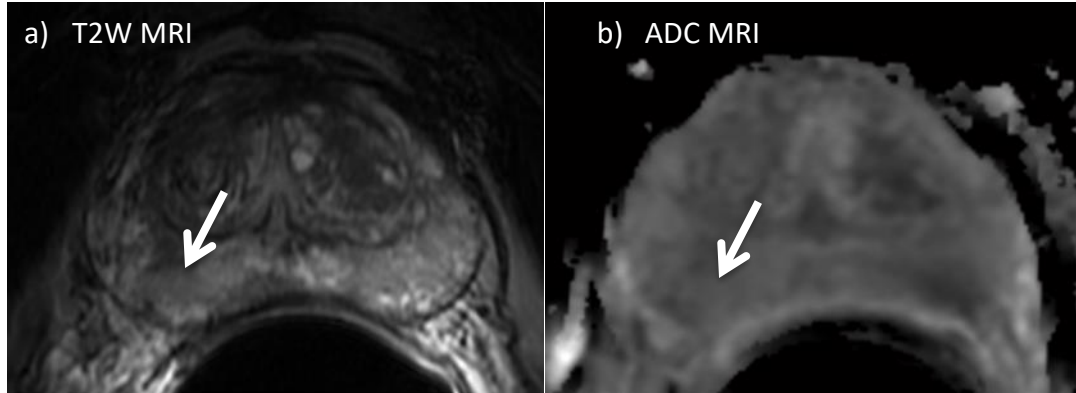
(a) T2W MRI of a prostate, showing a cancerous lesion as a hypointensity (arrow) in the PZ. (b) ADC map of the same slice, showing the lesion as hypointensity (arrow).
